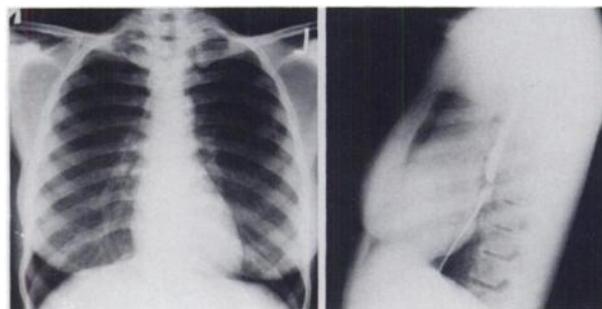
P-A and left lateral chest x-ray on admission showing no abnormality.
